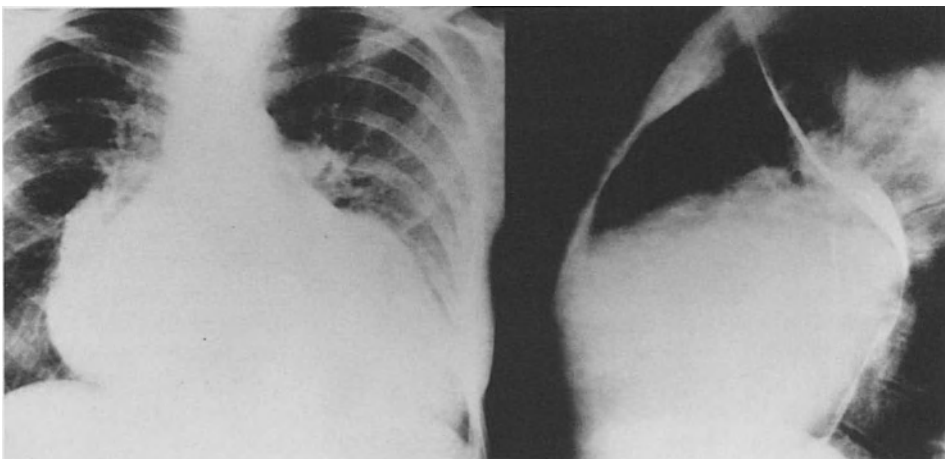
Chest X-ray in a case of gross mitral insufficiency demonstrating an aneurysmal left atrium protruding beyond the right cardiac border.
